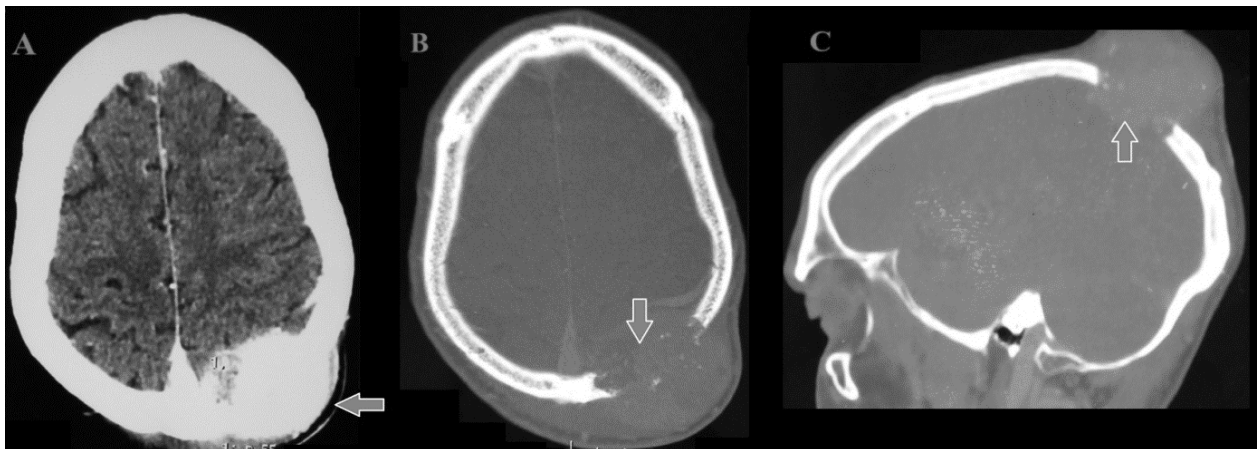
Preoperative brain CT scan. A: injected axial slide; B: bony window axial slide; C: sagittal bony window, showing an osteolytic left parietal lesion intensely enhanced after injection of the contrast product (red arrow).
